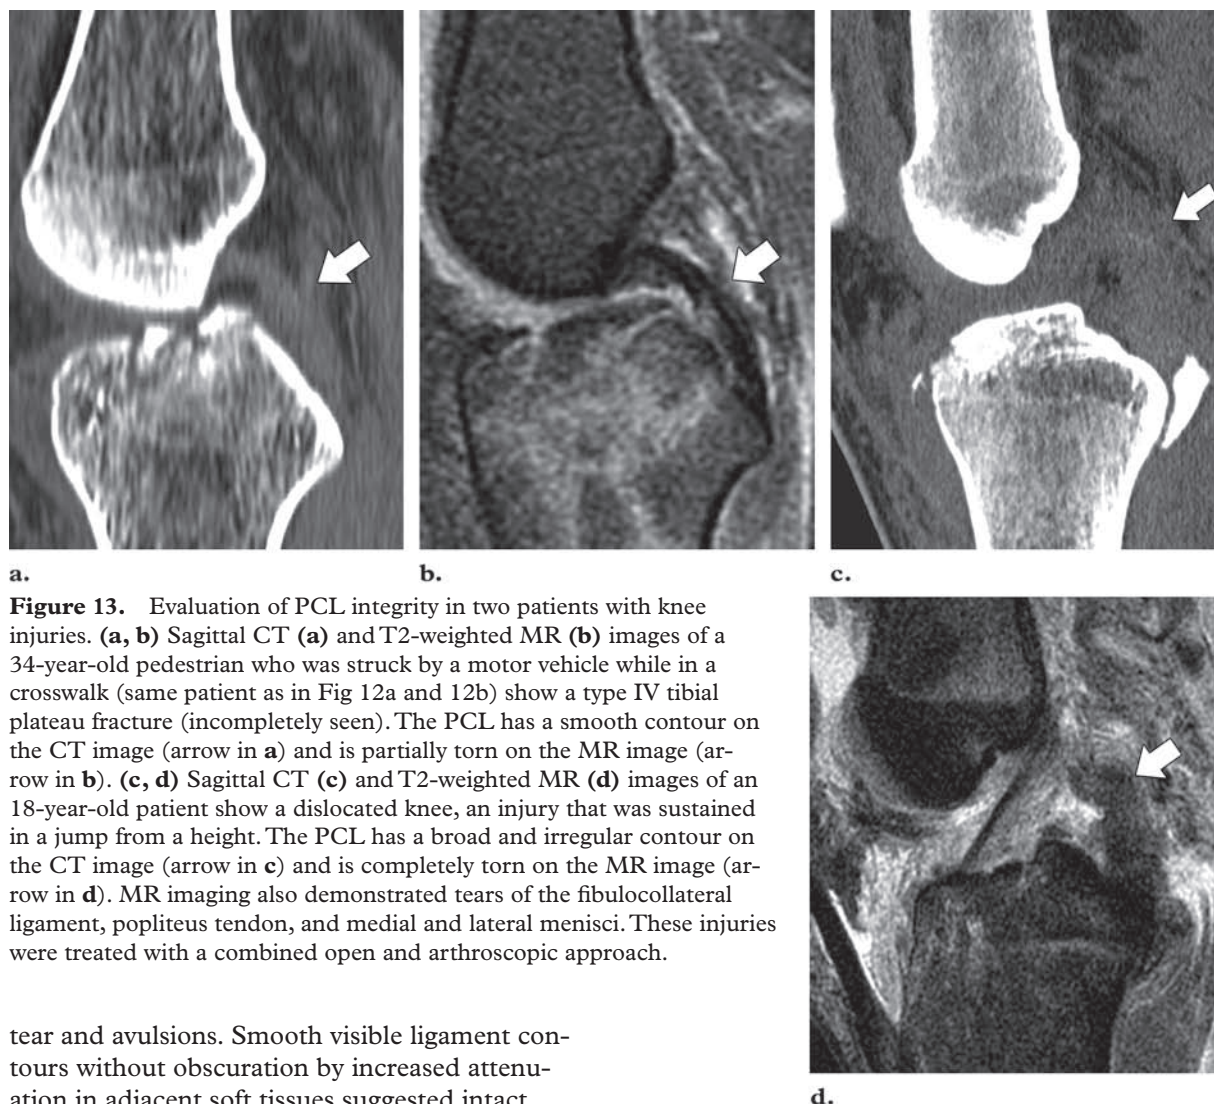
Evaluation of PCL integrity in two patients with knee injuries. (a, b) Sagittal CT (a) and T2-weighted MR (b) images of a 34-year-old pedestrian who was struck by a motor vehicle while in a crosswalk (same patient as in Fig 12a and 12b) show a type IV tibial plateau fracture (incompletely seen). The PCL has a smooth contour on the CT image (arrow in a) and is partially torn on the MR image (arrow in b). (c, d) Sagittal CT (c) and T2-weighted MR (d) images of an 18-year-old patient show a dislocated knee, an injury that was sustained in a jump from a height. The PCL has a broad and irregular contour on the CT image (arrow in c) and is completely torn on the MR image (arrow in d). MR imaging also demonstrated tears of the fibulocollateral ligament, popliteus tendon, and medial and lateral menisci. These injuries were treated with a combined open and arthroscopic approach.
